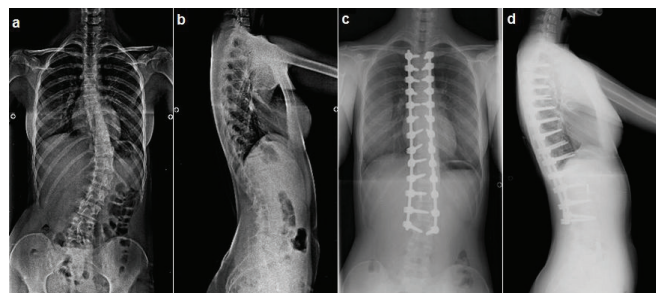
Preoperative and postoperative radiographs of an adolescent idiopathic scoliosis patient who underwent posterior instrumentation and fusion with segmental pedicle screws. a) preoperative anteroposterior view, b) preoperative lateral view, c) postoperative anteroposterior view, d) postoperative lateral view
